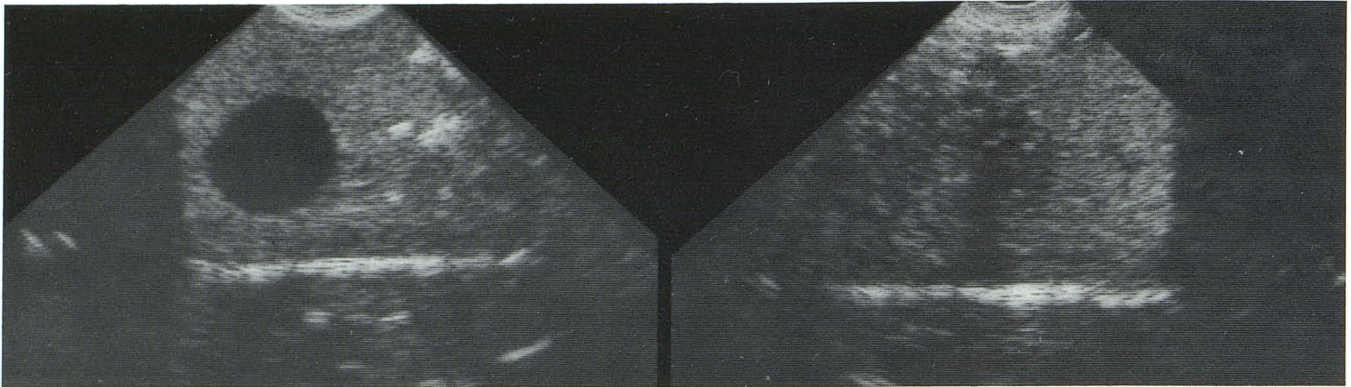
Hand injection of small volume of saline generates numerous echogenic foci (microbubbles) that fill in cyst. Injection needle is outside of ultrasound image plane.
